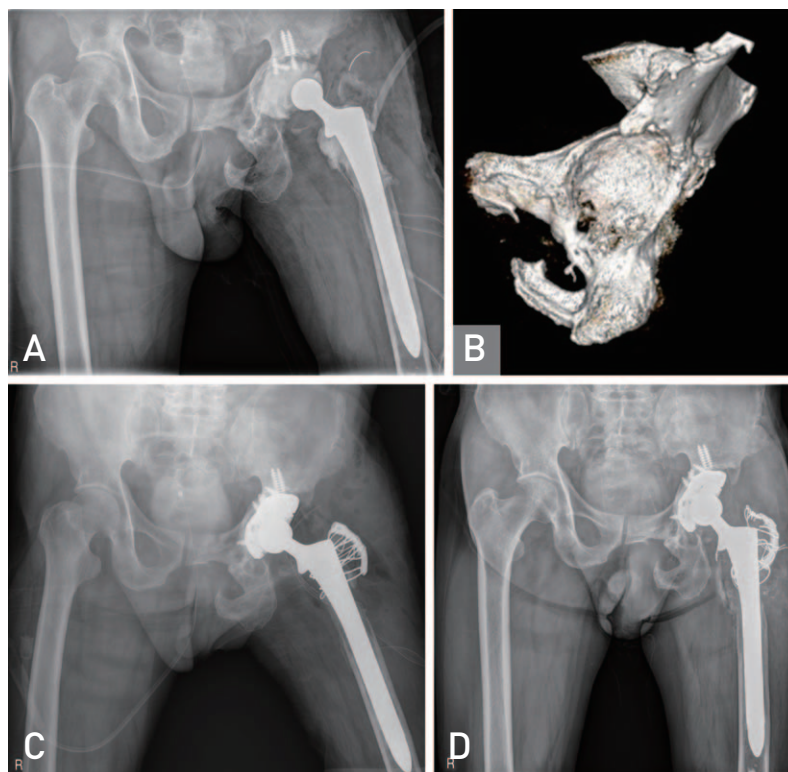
(A) Anteroposterior radiograph after undergoing 1st stage debridement for fourth time recurrent periprosthetic hip joint infection due to underlying chronic pelvic infection. (B) Three-dimensional computed tomography scan shows large bone defect of the acetabulum. (C) Immediate postoperative anteroposterior radiograph. (D) Three years postoperative anteroposterior radiograph shows a well fixed trabecular metal augment and the acetabular cup with bony ingrowth.
